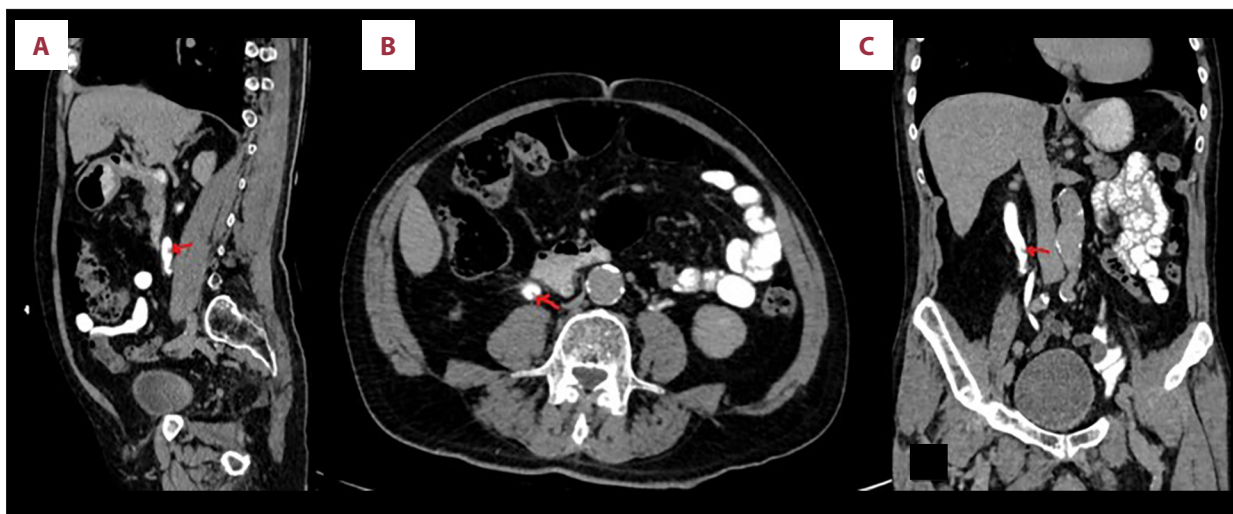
Contrast-enhanced computed tomography (CT) images demonstrating an endophytic filling-defect lesion (red arrows). (A) Sagittal view showing the lesion along the proximal ureter. (B) Axial view showing the intraluminal filling defect. (C) Coronal reconstruction confirming the location and extent of the endophytic lesion.
